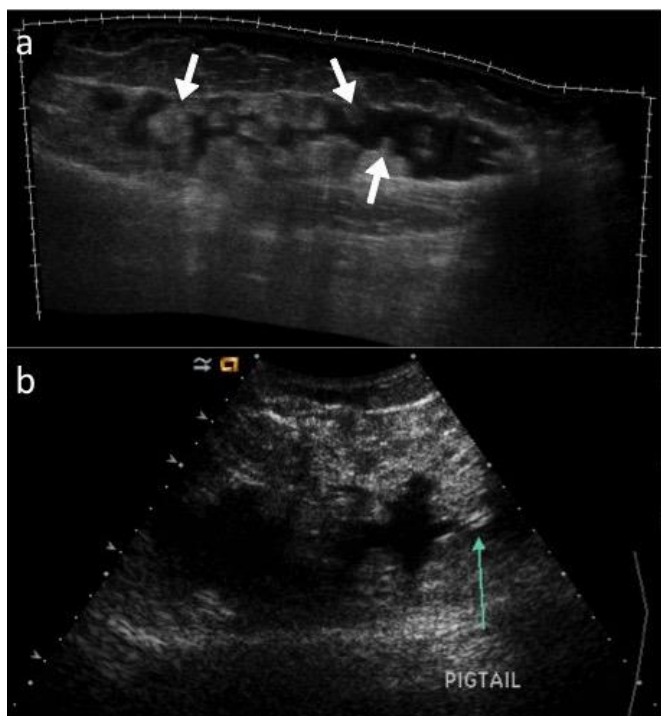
(left): 28 year-old-male with a Type I Morel-Lavallée lesion in the lateral left thigh. (a) Panoramic ultrasound from the day of trauma of the lateral thigh demonstrates a complex subcutaneous fluid collection with internal papillary projections (white arrows). (b) Transverse view of the fluid collection demonstrates subsequent placement of a drainage catheter within the collection. Technique: (a) Curvilinear transducer with harmonic imaging at 4MHz. (b) Curvilinear transducer with harmonic imaging at 3MHz.
